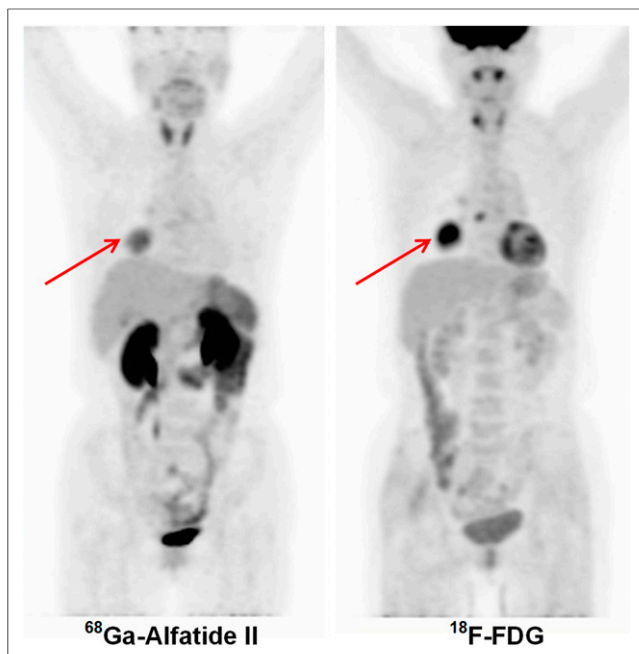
Distribution overview of ^{68}Ga -Alfatide II and ^{18}F -FDG in representative squamous carcinoma patient. Tumors are indicated by red arrows.
